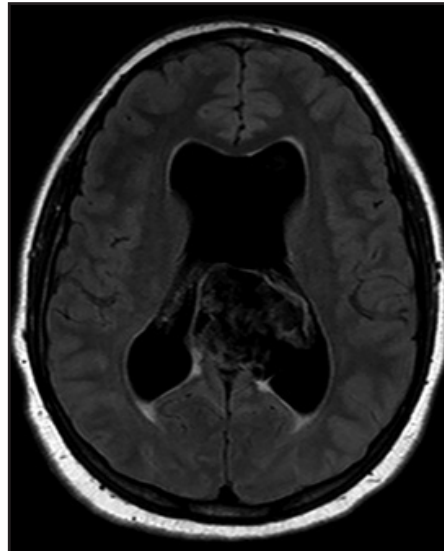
FLAIR axial image demonstrates incomplete fluid suppression. There is minimal periventricular FLAIR hyperintensity surrounding the mild lateral ventricle dilation suggesting CSF transependymal edema/resorption.
